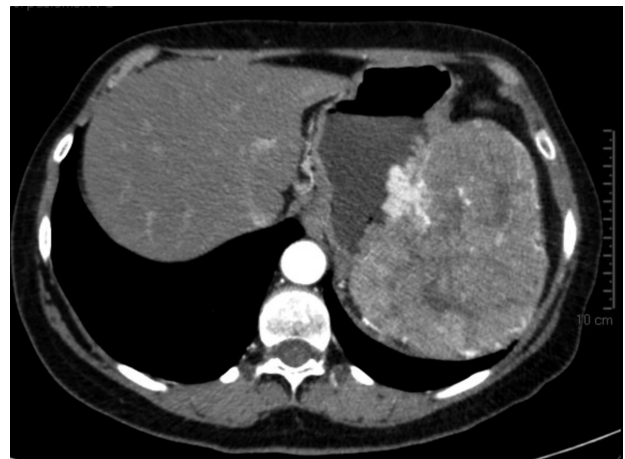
Contrast-enhanced CT image: inhomogeneous, extraluminal, tumor mass with irregular shape.
